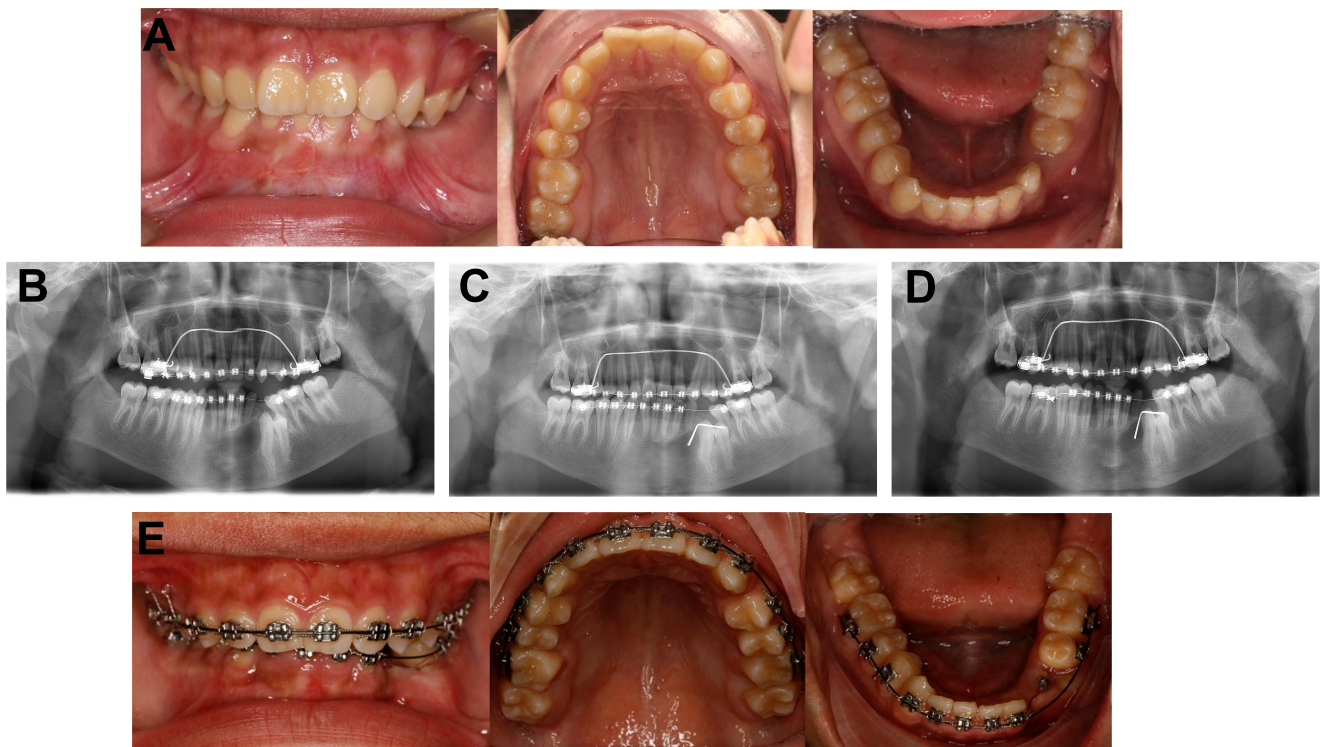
Intraoral photograph and panoramic radiographs during orthodontic treatment. (A) The photo before starting the orthodontic treatment. (B) After the enucleation of the lesion at tooth 48, the orthodontic treatment was used to open space. (C,D) Continuing decompression until the lesion in the left mandible was small enough to remove entirely by enucleation. (E) The photo during the orthodontic treatment.
